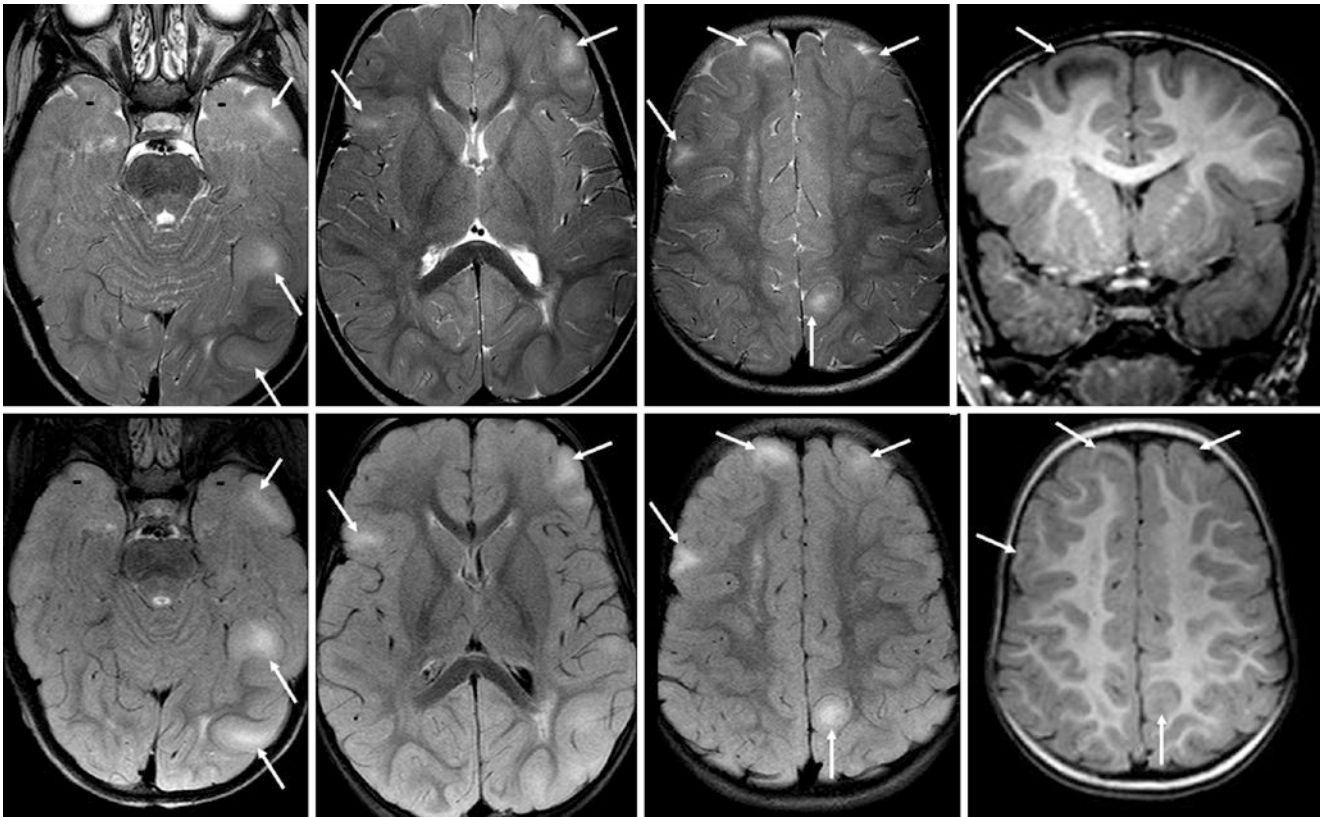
Comparison case of tuberous sclerosis. A 15.5-month-old with seizures underwent a 3T MRI, which depicted multiple cortical tubers (*thin arrows*) on axial SE T2WIs (*top, left three images*), coronal GE T1WI (*top, right*), FLAIR (*bottom, left three images*), and axial GE
